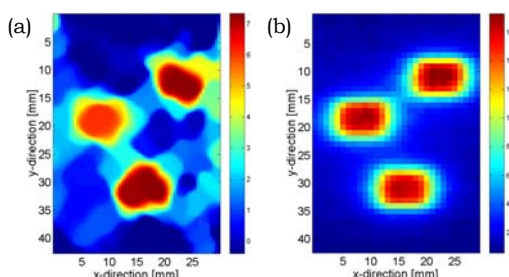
Dose distribution from inverse algorithm (a) and reference dose distribution from MRI (b).
